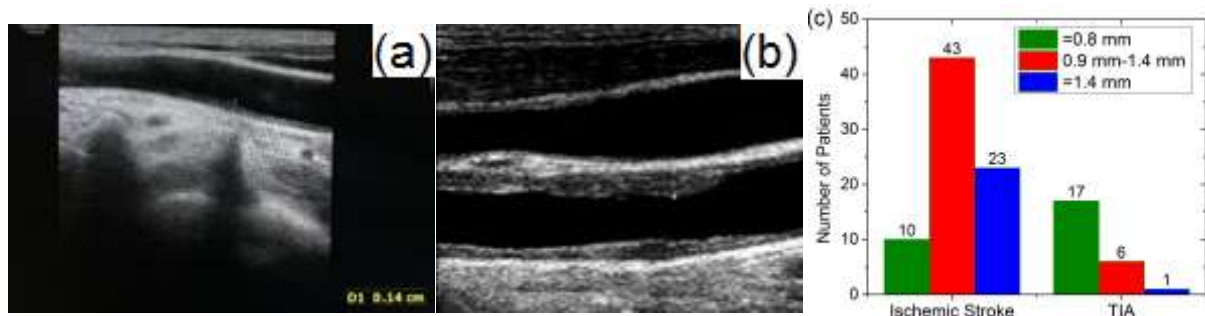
(a) Doppler US image showing increased intima media thickness of the carotid vessels, (b) Increased IMT measurement in left CCA²², and (c) Distribution of intima media thickening grading in stroke and TIA cases.
